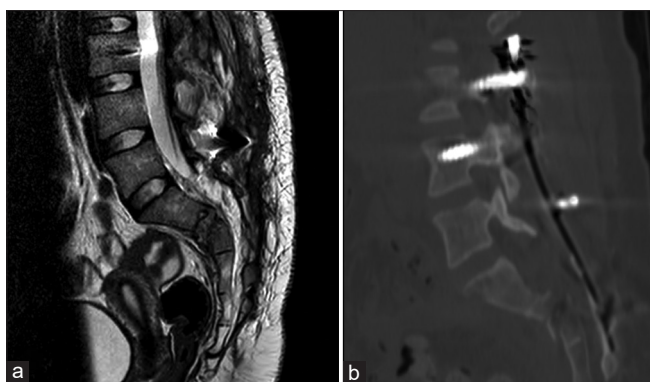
Postoperative sagittal lumbosacral magnetic resonance imaging (a) and computed tomography scan (b) showing satisfactory implant positioning and sagittal plane alignment
